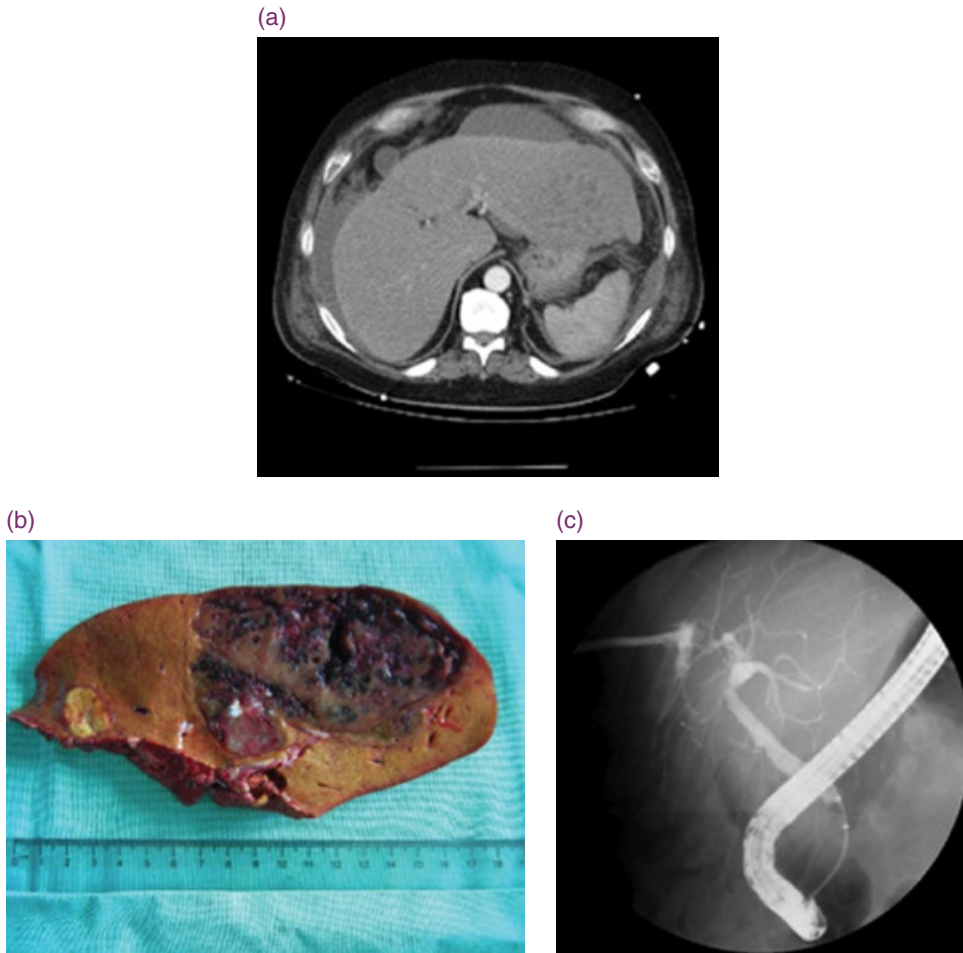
Hepatocellular carcinoma treated with radiological ablation therapies. (a) Computed tomography showing the cirrhotic liver and large tumor. (b) Resected tumor showing post-radiation necrosis. (c) Post-interventional cholangiogram showing bile leakage and accumulation into the necrotic area.
